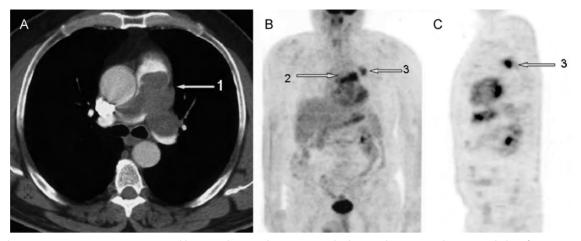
Pulmonary artery sarcomas in a 62-year-old man with acute dyspnoea wrongly diagnosed as acute pulmonary embolism (patient no.30). (A) Axial enhanced computed tomography shows filling defect occupying nearly the entire lumen of the main pulmonary artery (arrow 1) and extending into the origin of both pulmonary arteries. (B and C) F-18 fluorodeoxyglucose positron emission tomography with integrated computed tomography (FDG-PET/CT) showing intense hypermetabolism in the main pulmonary artery (arrow 2), in the origin of the right and left pulmonary arteries and in the left upper lobe (metastasis; arrow 3).
